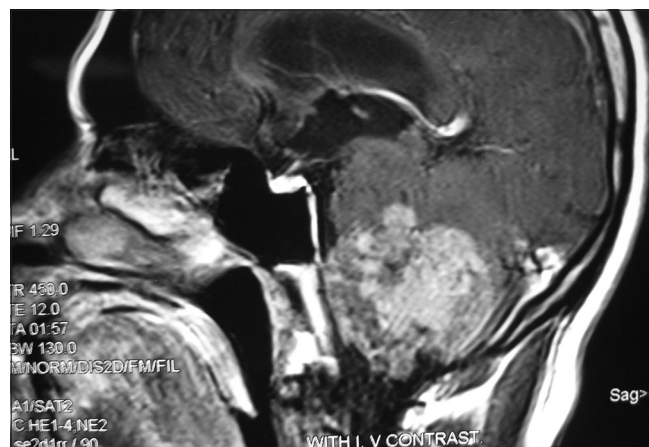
Contrast-enhanced sagittal magnetic resonance imaging shows inhomogeneously enhanced petroclival region space-occupying lesion extending up to the level of C1 vertebra
